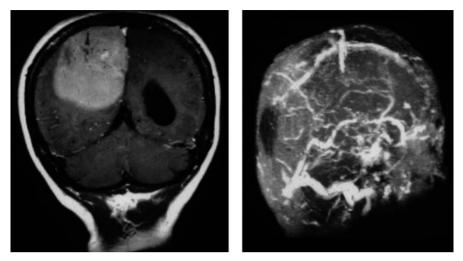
Posterior third, right, parasagittal Type VI meningioma. *Left*: Coronal MRI – T1 sequence after gadolinium. *Right*: pre-operative venous MR, lateral view, showing total occlusion of the sinus and compensatory drainages through intra-osseous emissary veins which communicate with extracranial circulation. Exposure may destroy these collateral drainages and lead to brain swelling
